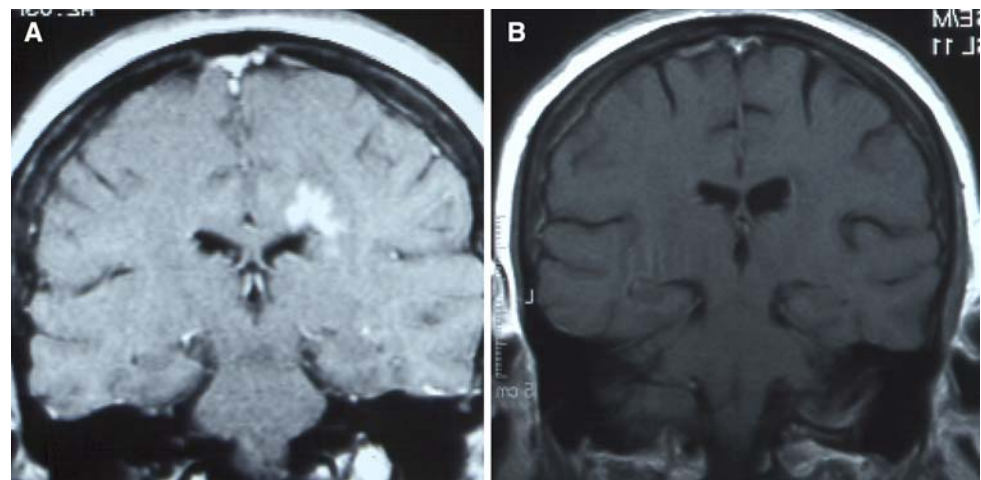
MRI studies before (a) and after (b) erlotinib therapy
